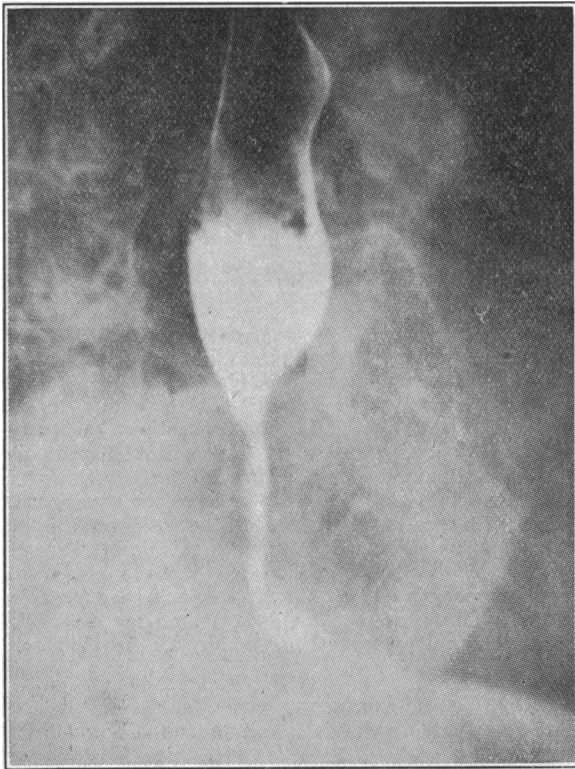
Radiograph taken in standing position showing partial stricture with irregular wall some distance above diaphragm, resembling carcinoma.
